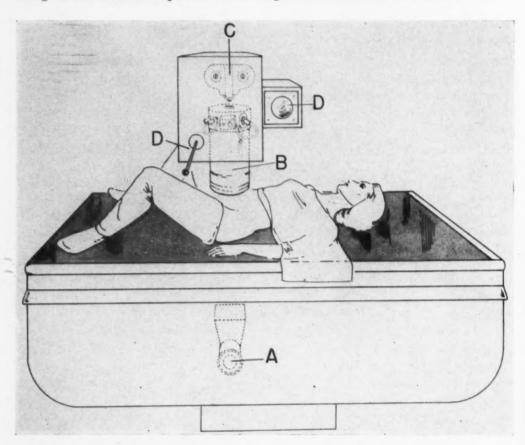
A, X-ray source. B, Image intensifier. C, Camera. D, Viewing system.
